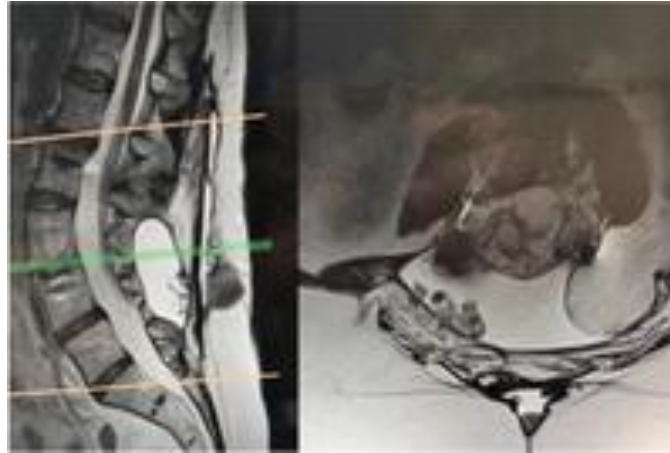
Preoperative MRI demonstrating a hernia defect containing retroperitoneal fat. A. Thecal sac; B. Retroperitoneal fat; C. Fluid collection.
